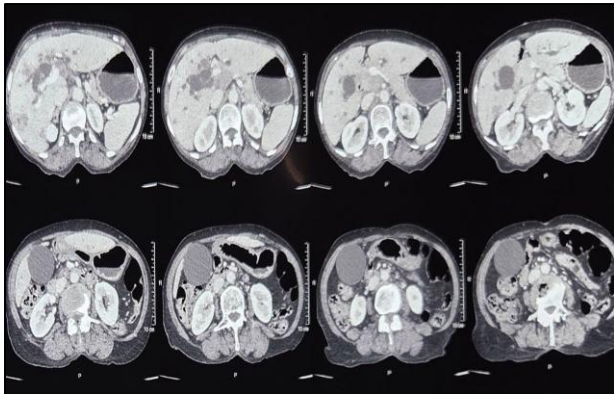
CT abdomen suggestive of intra-abdominal mass with ascites.
